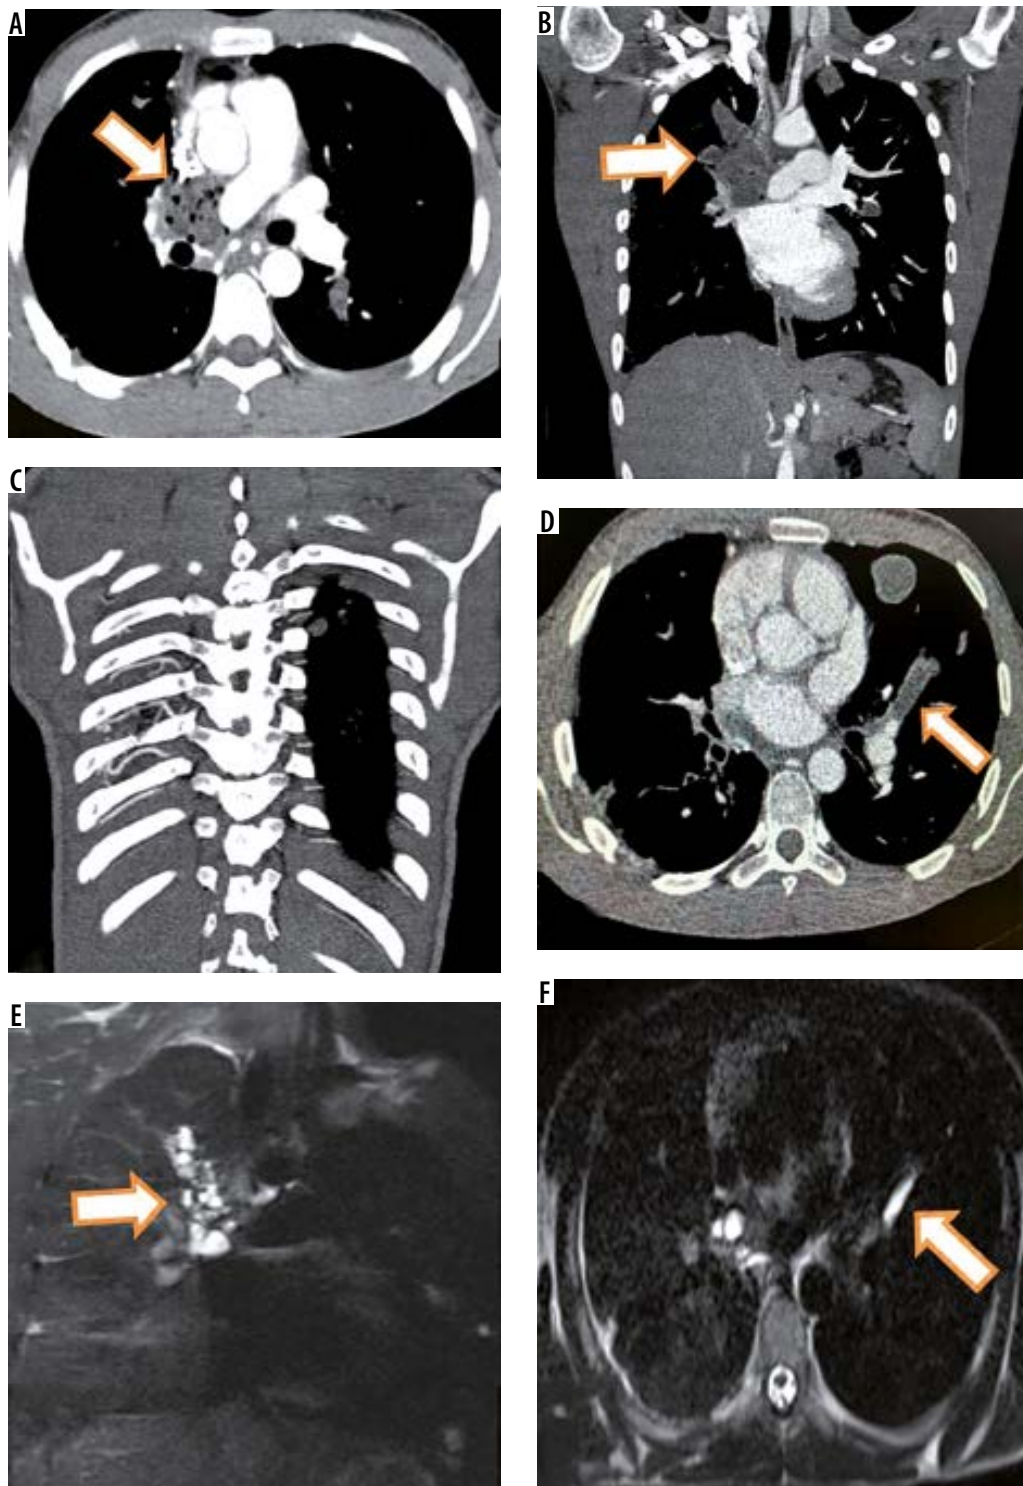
Intravascular pulmonary hydatid cyst in right main and left branch pulmonary artery. Axial (A) and coronal (B) computed tomography (CT) images reveal hypodense filling defects in right main pulmonary artery with extension into right upper lobar pulmonary artery with air foci inside (arrows in A and B). Coronal T2-W image (E) shows multiple cysts corresponding to right main and upper pulmonary lobar artery suggesting diagnosis of intravascular hydatid cysts. The patient showed hypertrophied intercostal (C), bronchial and inferior phrenic arteries. Axial CT image (D) in the same patient also shows left branch pulmonary artery hypodense filling defect which was hyperintense on T2-W image (F)
